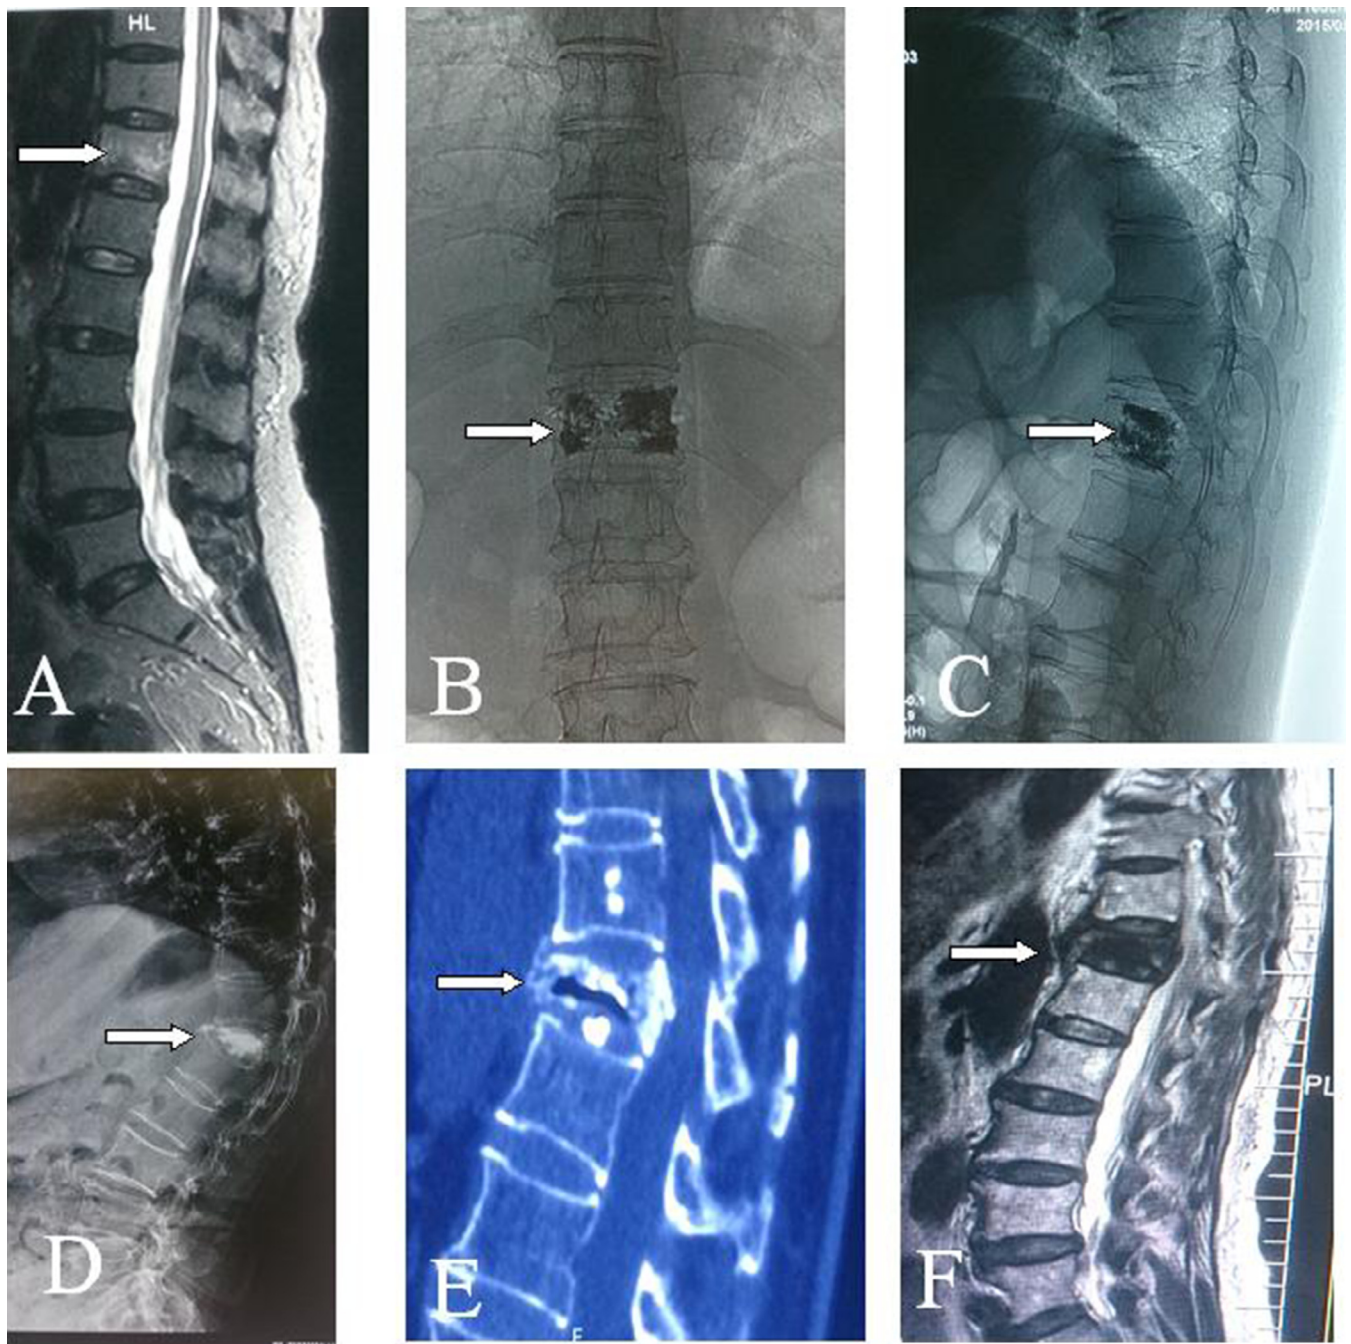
(A) MRI T2-weighted images showed high signal intensity on the T12 vertebra with compression (white arrow). (B–C) A total of 4.5 mL of polymethylmethacrylate (PMMA) bone cement was injected, and cement diffusion occurred evenly and was achieved end plate-to-end plate (white arrow). (D) Plain radiograph showed T12 vertebra collapse, with kyphosis angle of  $45^{\circ}$  (white arrow). (E) CT reconstruction shows the T12 vertebral body collapse with intravertebral vacuum (white arrow). (F) MRI T2-weighted images demonstrated low signal intensity on T12 (white arrow).
